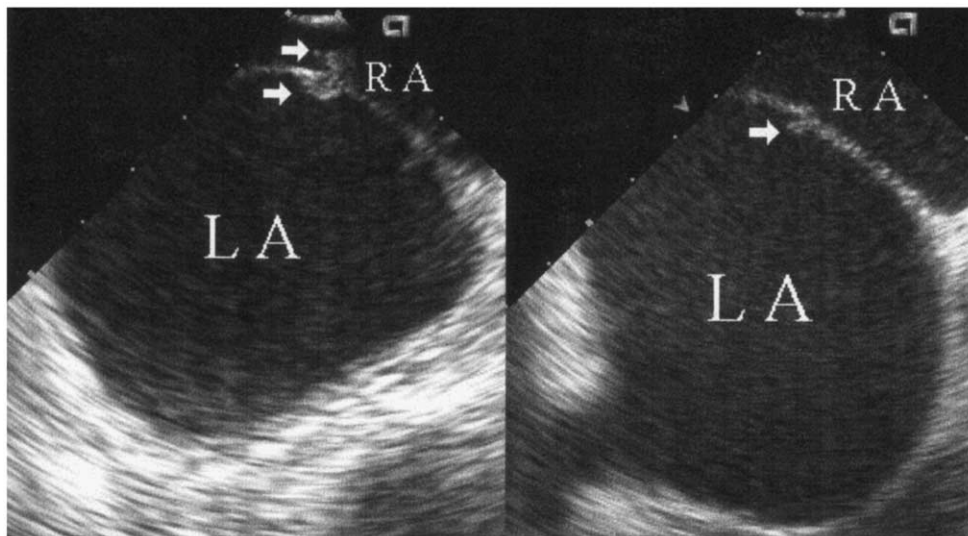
Intracardiac echocardiography images with transducer placed in the right atrium (RA) demonstrate a single, linear, and mobile thrombus (arrow, size  $7.9 \times 4.2$  mm) attached at the sheath of lasso (left upper panel), pulling the sheath/lasso with thrombus back (right upper panel) and withdrawal of thrombus from the left atrium (LA) (left lower panel) into the RA (right lower panel). Ao = aorta; LV = left ventricle. Other abbreviations as in [Figure 1](#).
